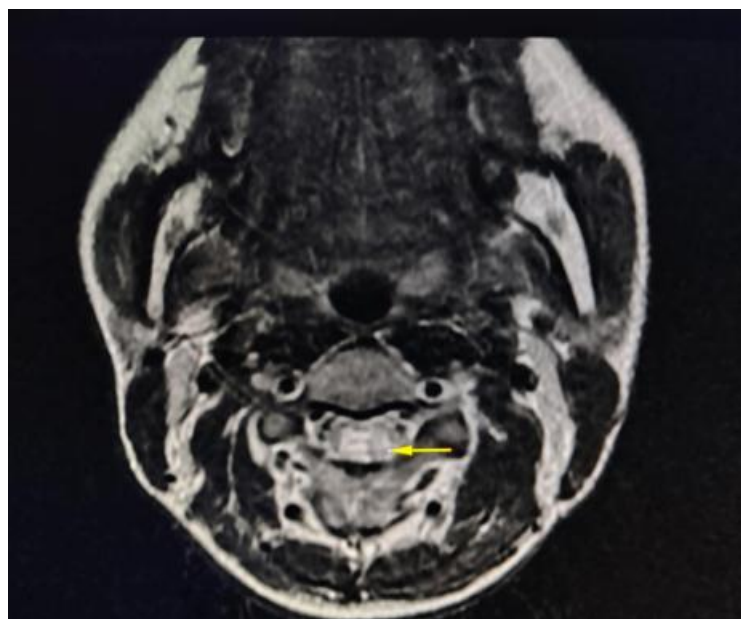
Axial T2-weighted MRI shows diffuse hyperintensity within the cervical cord, corresponding to the same segment
